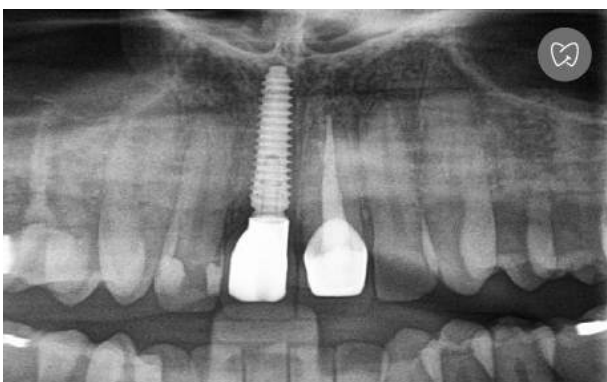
Post OP Radiograph
